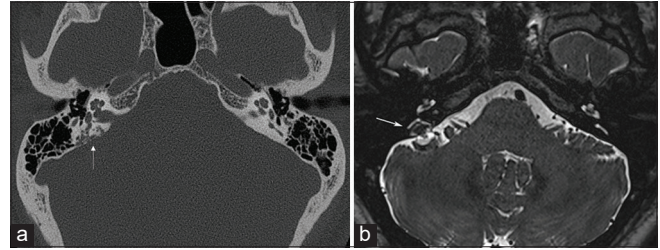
A 40-year-old man with endolymphatic sac tumor. (a) Axial high-resolution computed tomography image reveals focal bony destruction in the region of the right endolymphatic sac (arrow) (b) axial T2-weighted image at the same level shows a heterogeneously hyperintense mass (arrow).
